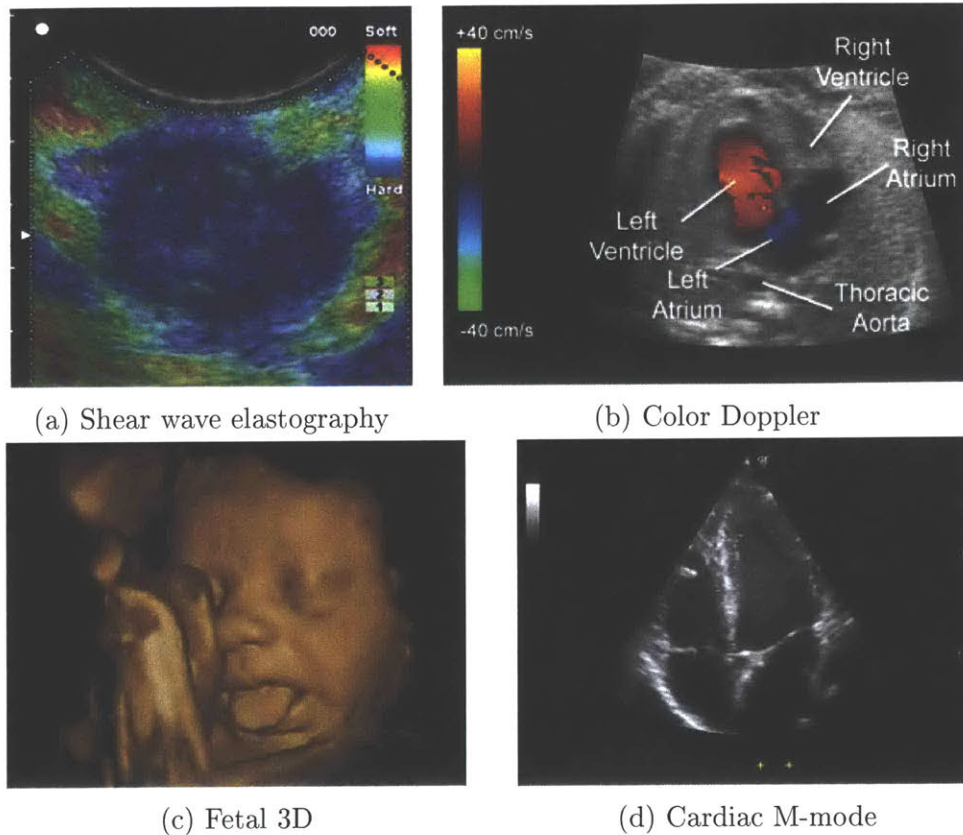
Various ultrasound imaging modes
